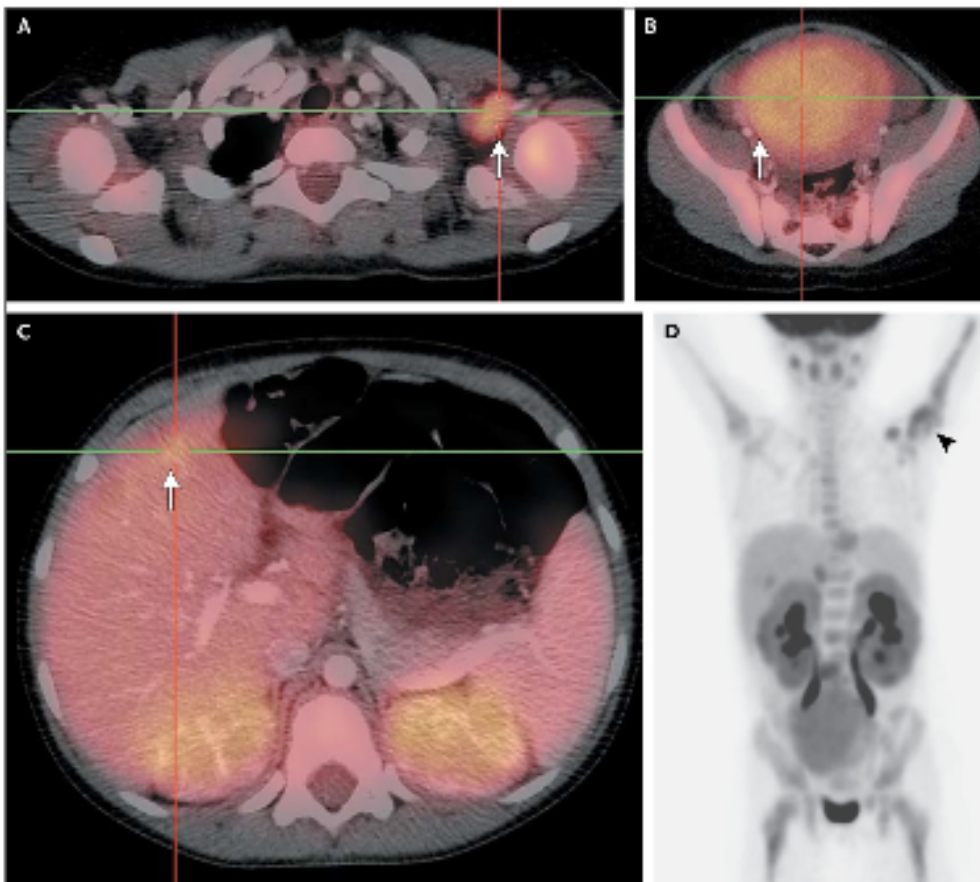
Fused FDG PET and CT Images of the Chest and Abdomen with Color Overlay.
